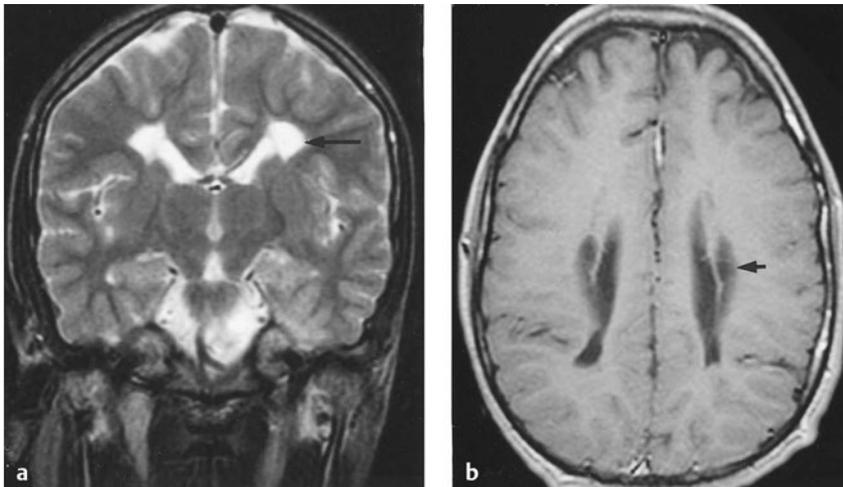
(a) Axial and (b) sagittal magnetic resonance images demonstrating periventricular leukomalacia in a pediatric patient with spastic diplegia.
